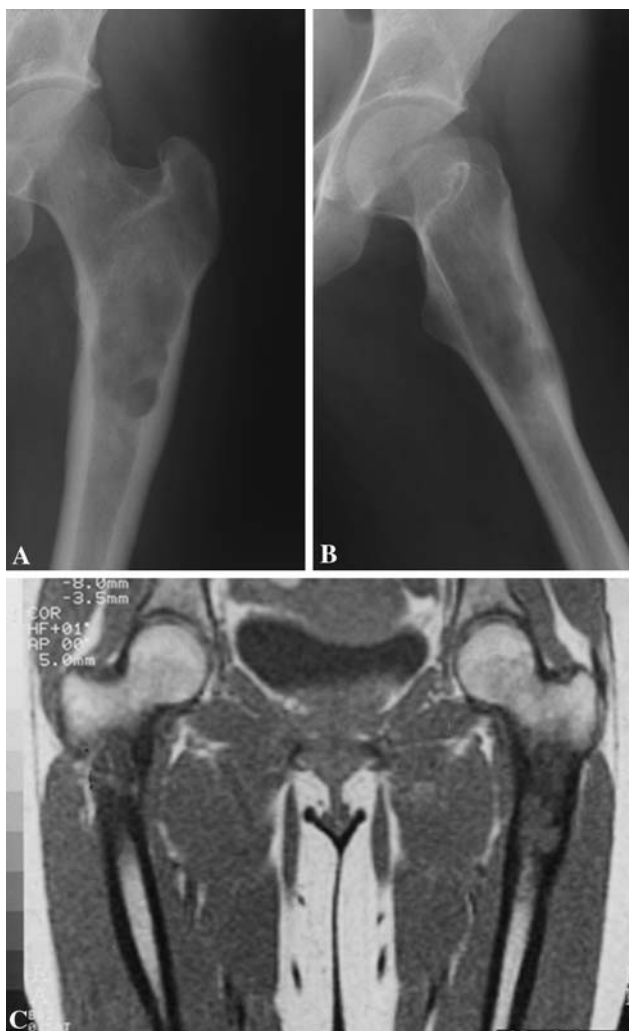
A CS of the left proximal femur is seen in these radiographs. In the (A) AP and (B) lateral projections, the inner lateral and posterior cortex is invaded (moderate scalloping) by the tumor. The cortical augmentation (enlargement, Grade I) is also evident. (C) The definition of the intramedullary tumor involvement is enhanced by MRI.
